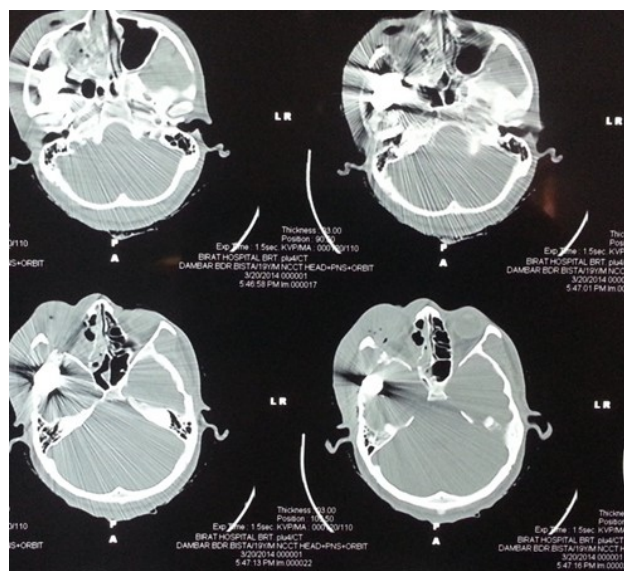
A CT head and orbit showing a large metallic body in the right temporal fossa along with contusion and smaller bone fragments. There is destruction of the eye ball suggesting it as the entry point (A). 3D reconstruction showing the defect in the orbital wall through the bullet trasversed (B).
